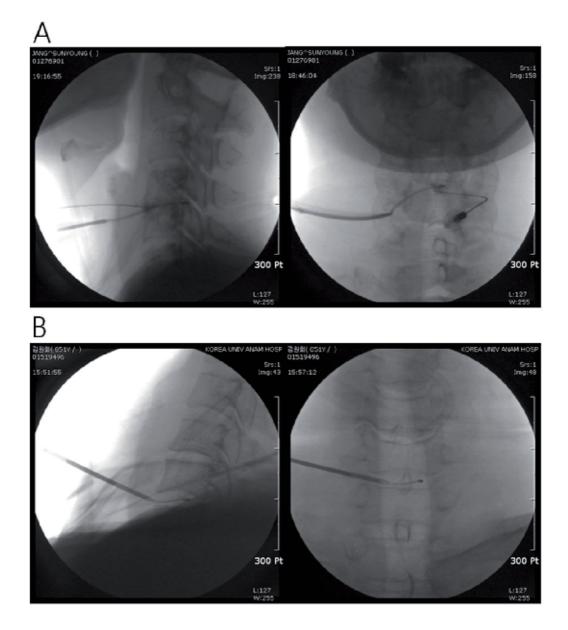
Exact positions of the L'DISQ-C wand tip (arrow) placed in the center of herniation. C-arm fluoroscopy was used in anteroposterior and lateral planes to confirm the correct placement with reference to MRI studies. (A) Placing the tip of the L-DISQ catheter into the herniated disc. (B) Cervical disc decompressions were performed using L-DISQ catheter with fluoroscopic guidance
